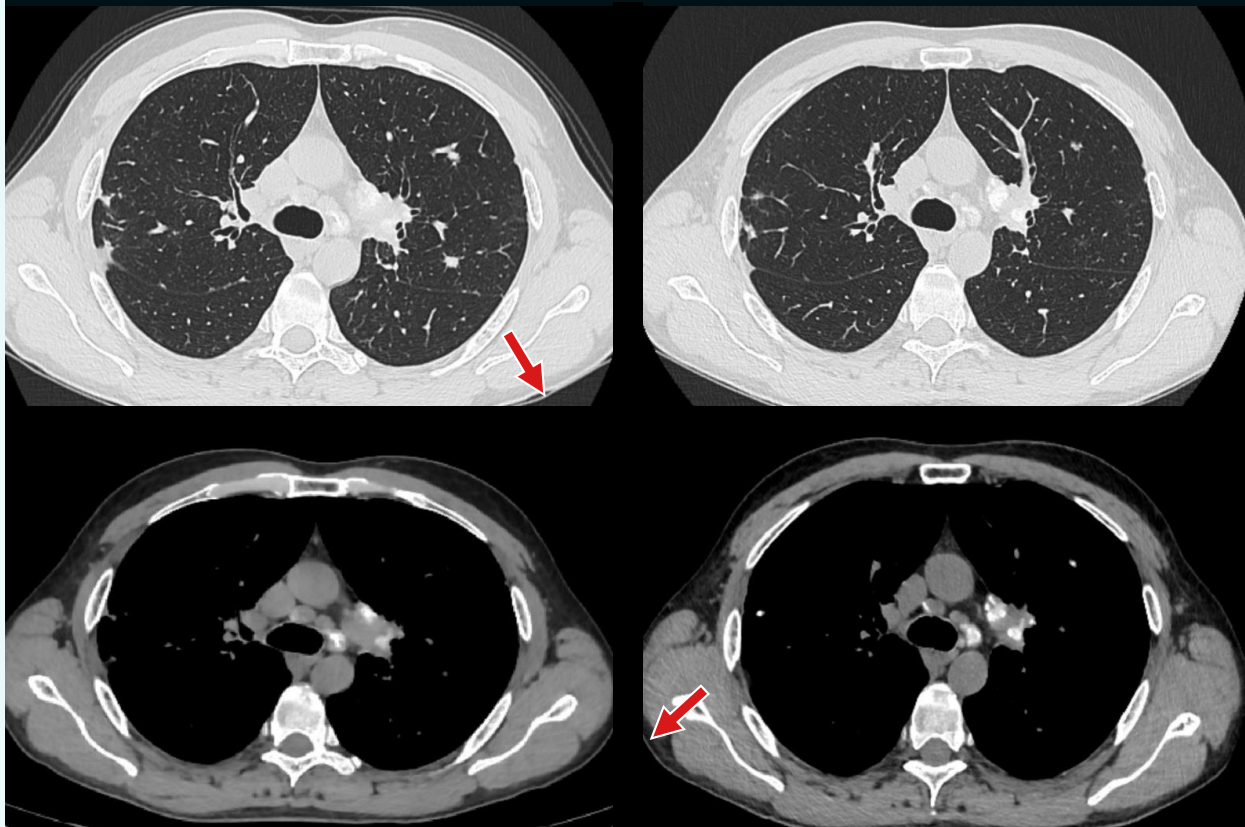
The imaging evolution of the sarcoidosis after 6 months of corticoid therapy with Methylprednisolone (initial chest CT in the left half of the image; CT re-assessment in the right half of the image). The significant regression in size of the multiple bilateral pulmonary nodules, without a significant change of the hilar and mediastinal lymphadenopathies.
